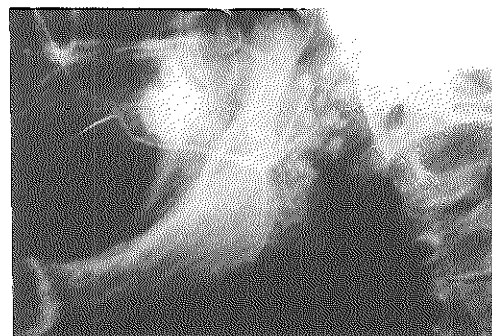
Lateral X-ray view during sialographic examination of the same patient as in Fig. 6a. Small, cystic dilatations of the ductal system are filled with contrast. The main duct is not dilated.
